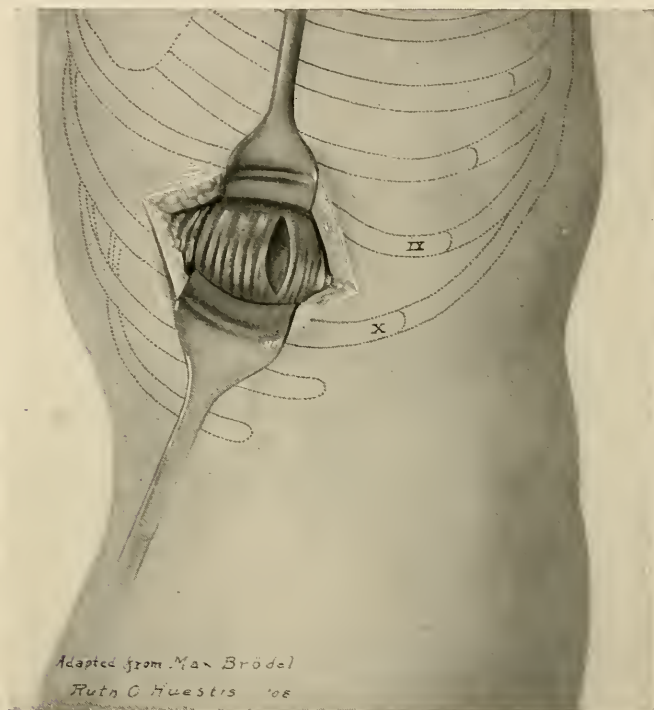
Transthoracic approach to the liver.
